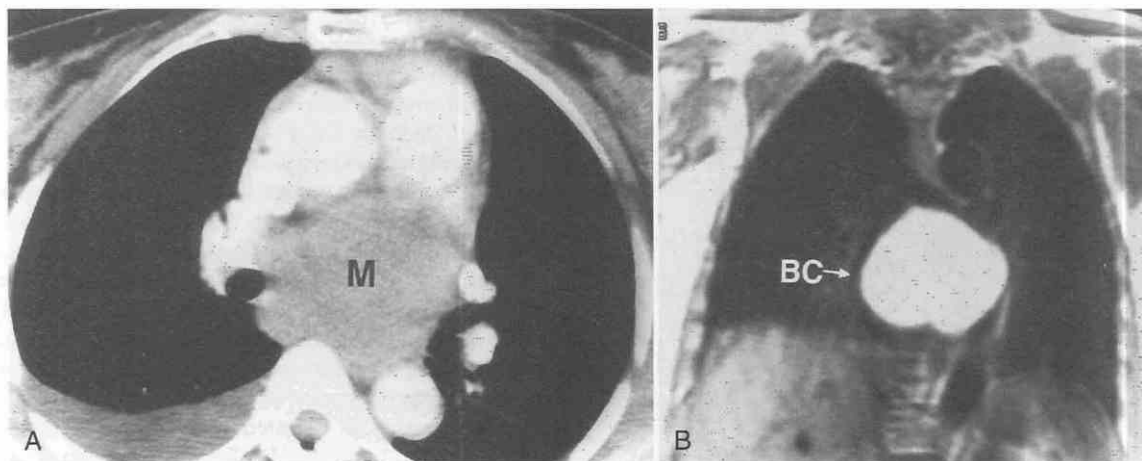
Bronchogenic cyst. A, CT shows a large homogeneous mass (M) of soft tissue attenuation in subcarinal region. B, Coronal T1-weighted MR image shows high signal intensity within the mass (BC), caused by viscous cyst fluid.
